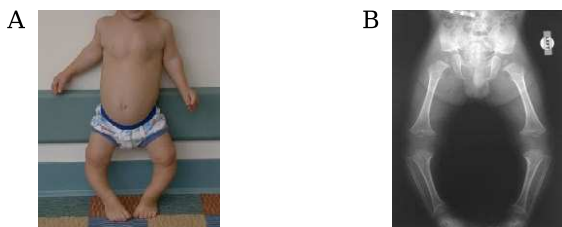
(A) Dramatic *varus* deformation of a child's lower limbs and (B) the corresponding radiograph [155].
